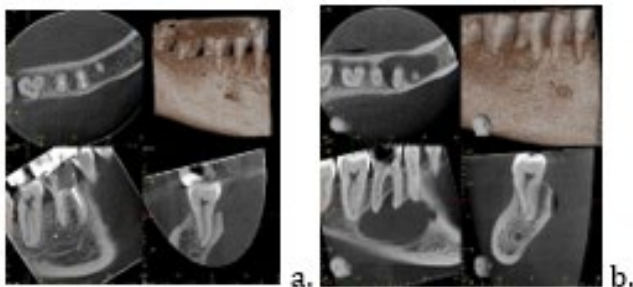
a, b second mandibular molars with C-shape configurations, CBCT images.
